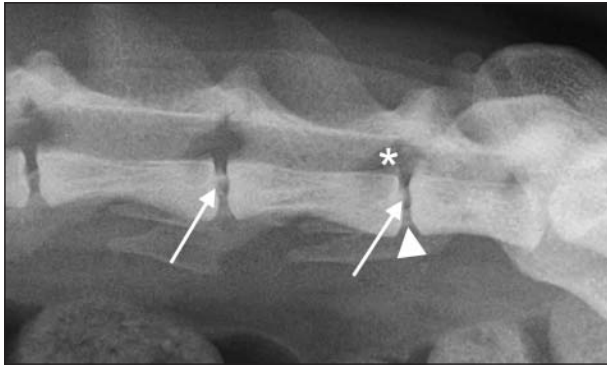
Same lateral radiographic image (magnified) as in Figure 1. Notice mineralization of the L5-6 and L6-7 disks (arrows). Additionally, narrowing of the L6-7 space (arrowhead) and mineral opacity at the L6-7 neural foramen (asterisk) are evident.
